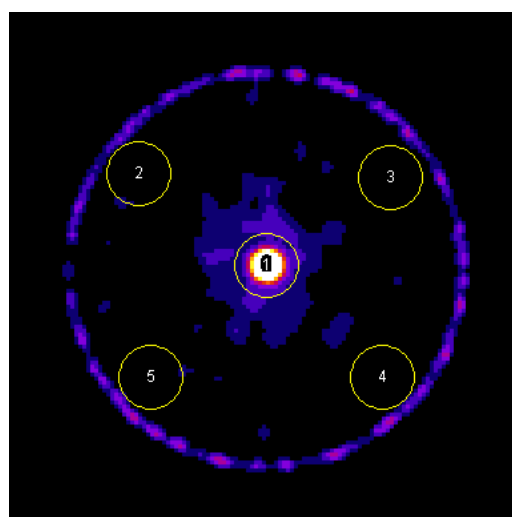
Axial SPECT slice from experimental measurement.
